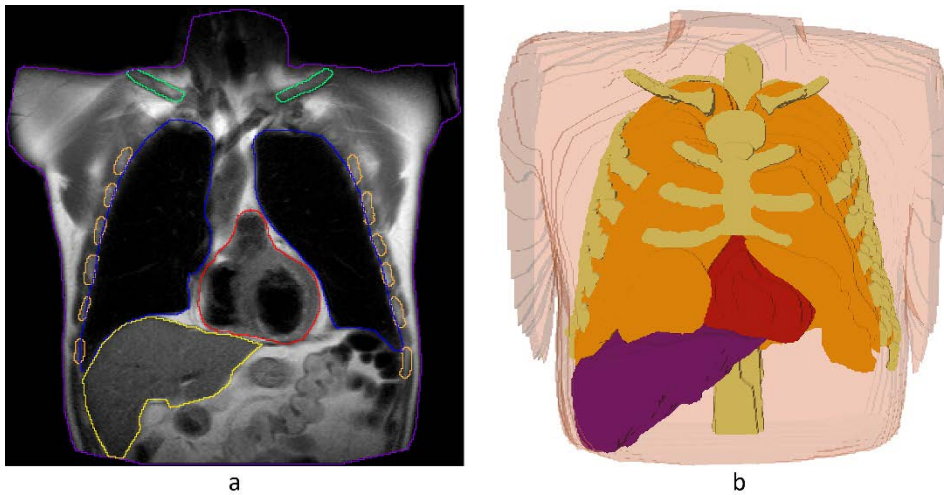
Generation process of the 3D torso model. (a) Slice of whole-torso anatomical MRI in coronal plane, showing manually delineated contours of several organs and anatomical structures: body contour (*purple*), collarbones (*green*), lungs (*blue*), ribs (*orange*), epicardium (*red*) and liver (*yellow*). (b) Raw isosurfaces (exported from Seg3D) resulting from the segmentation of low-resolution whole-torso MRI, showing bones, lungs, epicardium and liver within the body contour rendered with transparency.
